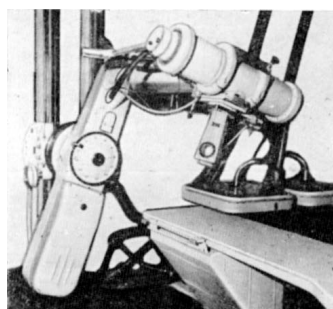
X-ray therapy device RUM-17
